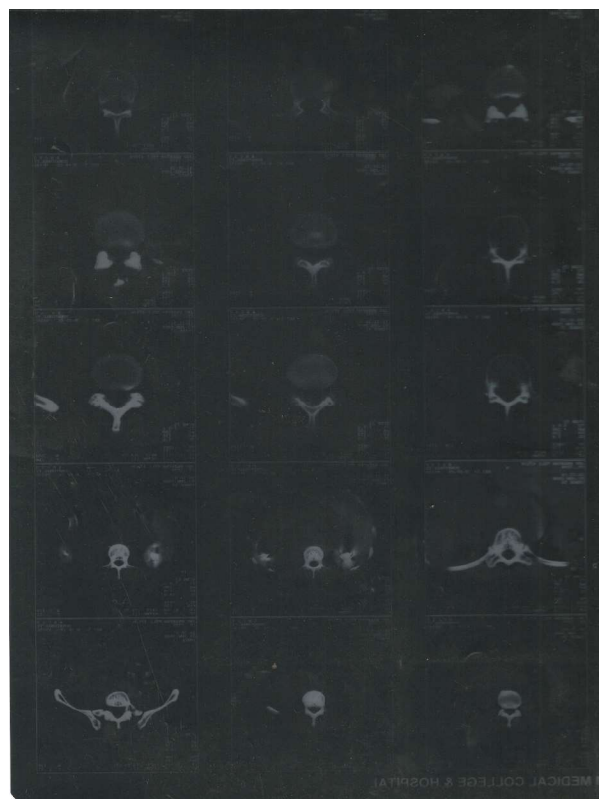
CT scan showing lobulated retroperitoneal pre and paravertebral soft tissue mass suggestive of lymphadenopathy.
